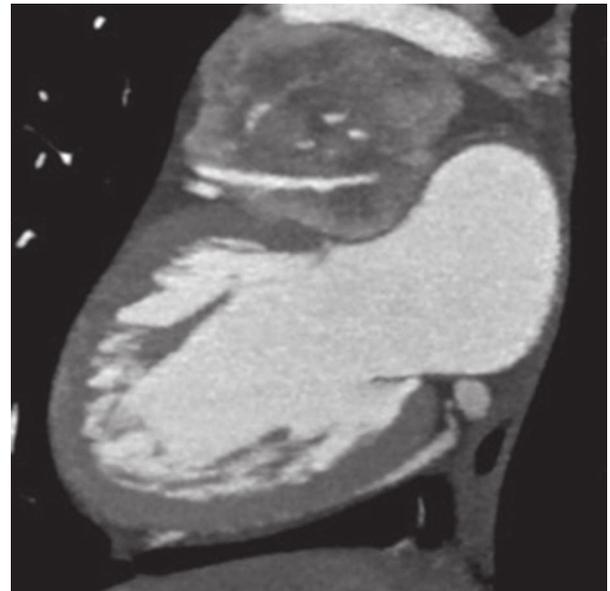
Coronary computed tomography. Mass located in the left atrioventricular groove.
